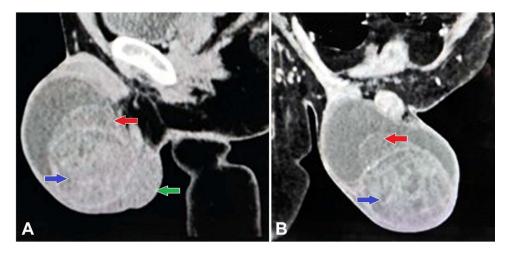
Contrast-enhanced computed tomography (CECT) of the pelvis in sagittal (A) and coronal (B) views revealing a heterogeneously enhancing mass lesion in the right paratesticular region (blue arrow) accompanied by a surrounding hydrocele. The right testis is visualized separately (red arrow), and the left testis appears normal (green arrow).
